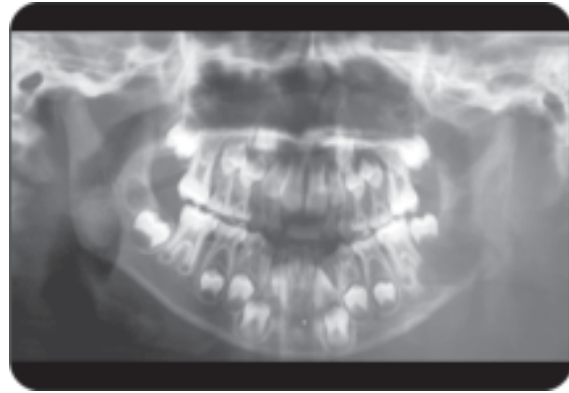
Radiograph of osteosarcoma-II
